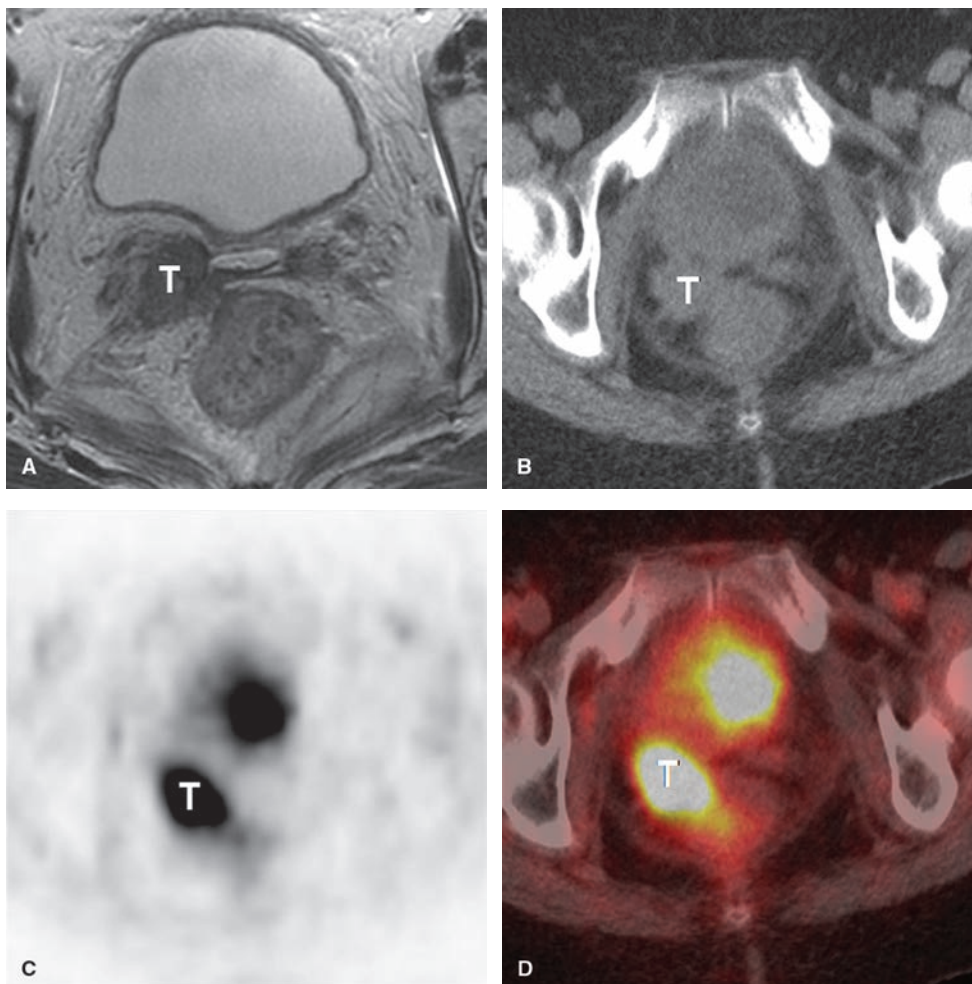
Recurrent cervical carcinoma. Axial oblique T2W FSE MR (A), unenhanced CT (B), FDG-PET (C), and fused PET/CT (D) images show cervical cancer recurrence in the vaginal vault (T in A–D).
